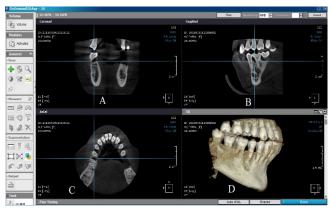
preoperative CBCT assessment of defect (A-coronal view, B-sagittal, C-axial and D-3D views).
